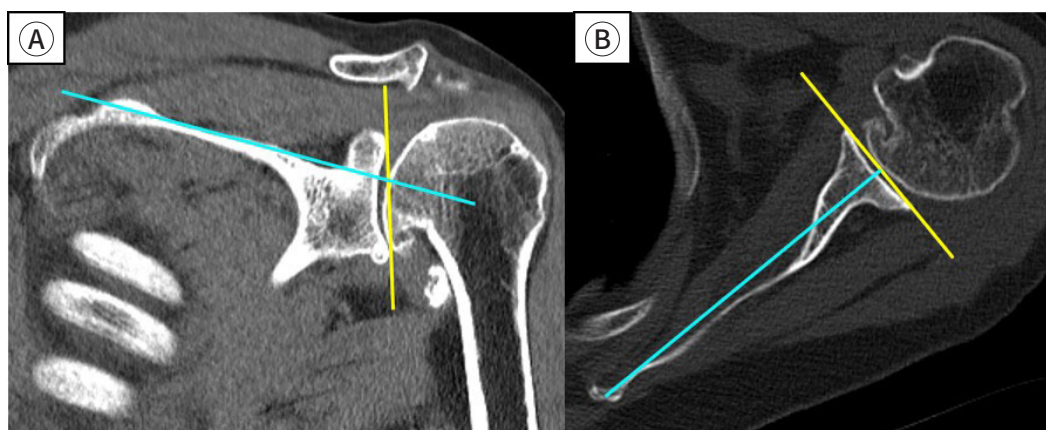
CT: glenoid inclination (A), glenoid version (B). Provided by the authors.
